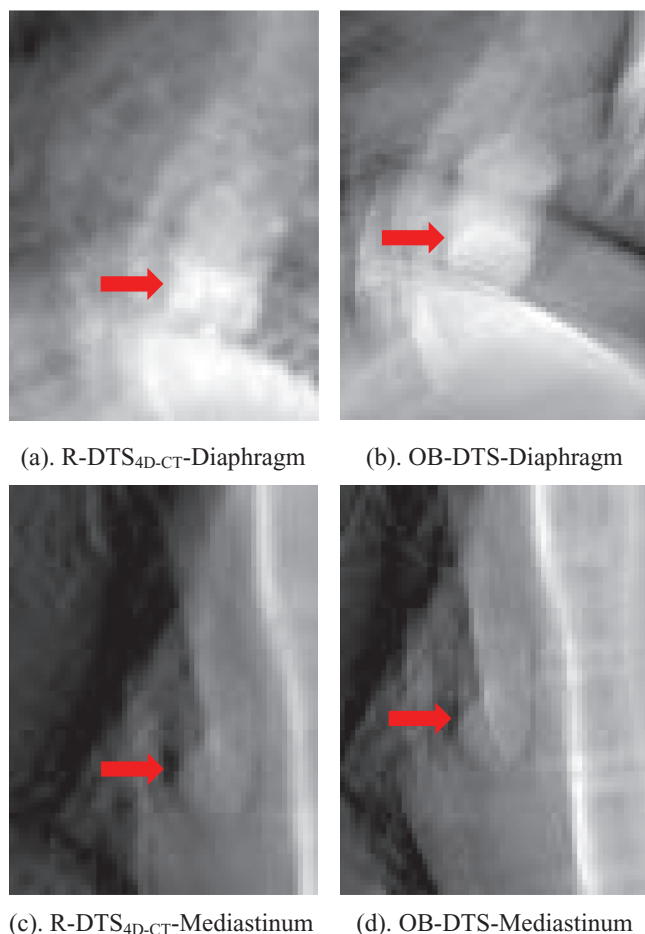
Comparison between the slices from (a) and (c) R-DTS_{4D-CT} and (b) and (d) OB-DTS for the two extreme outliers of failed registration (tumor locations indicated by red arrows).
